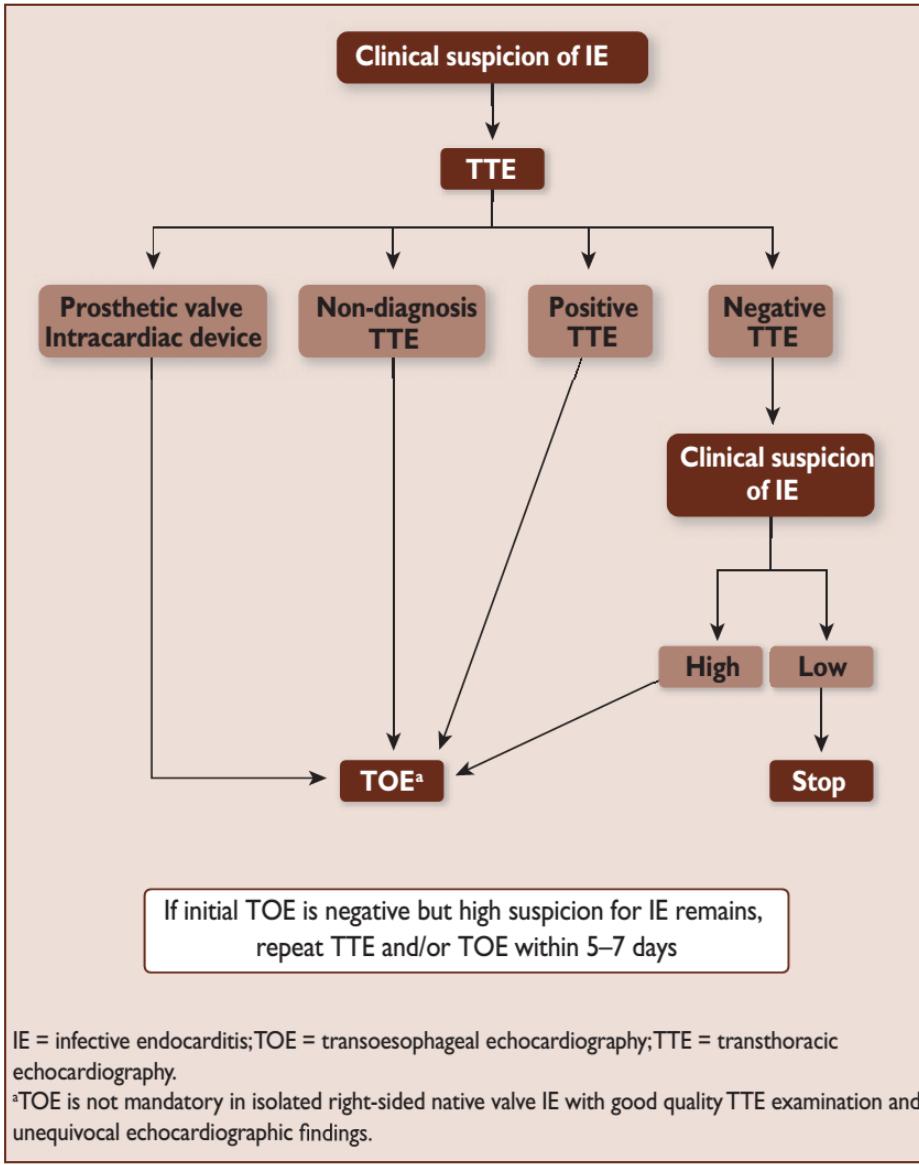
Indications for echocardiography in suspected infective endocarditis.
